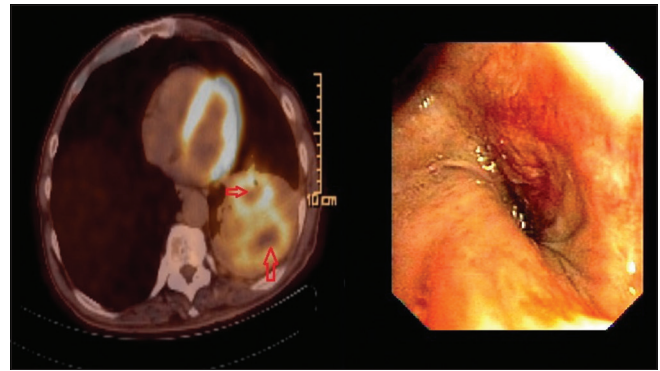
Appearance of submucosal infiltration at the entrance of the left lower lobe on positron emission tomography-computed tomography
